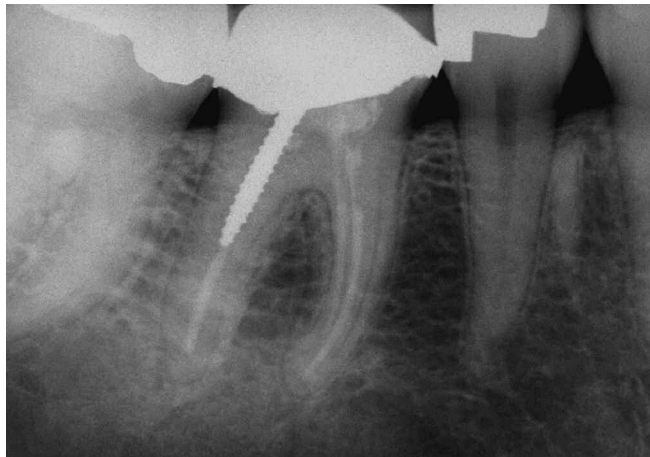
A radiograph of a mandibular right first molar demonstrates a PFM crown, a screw post and inadequate endodontic treatment.
